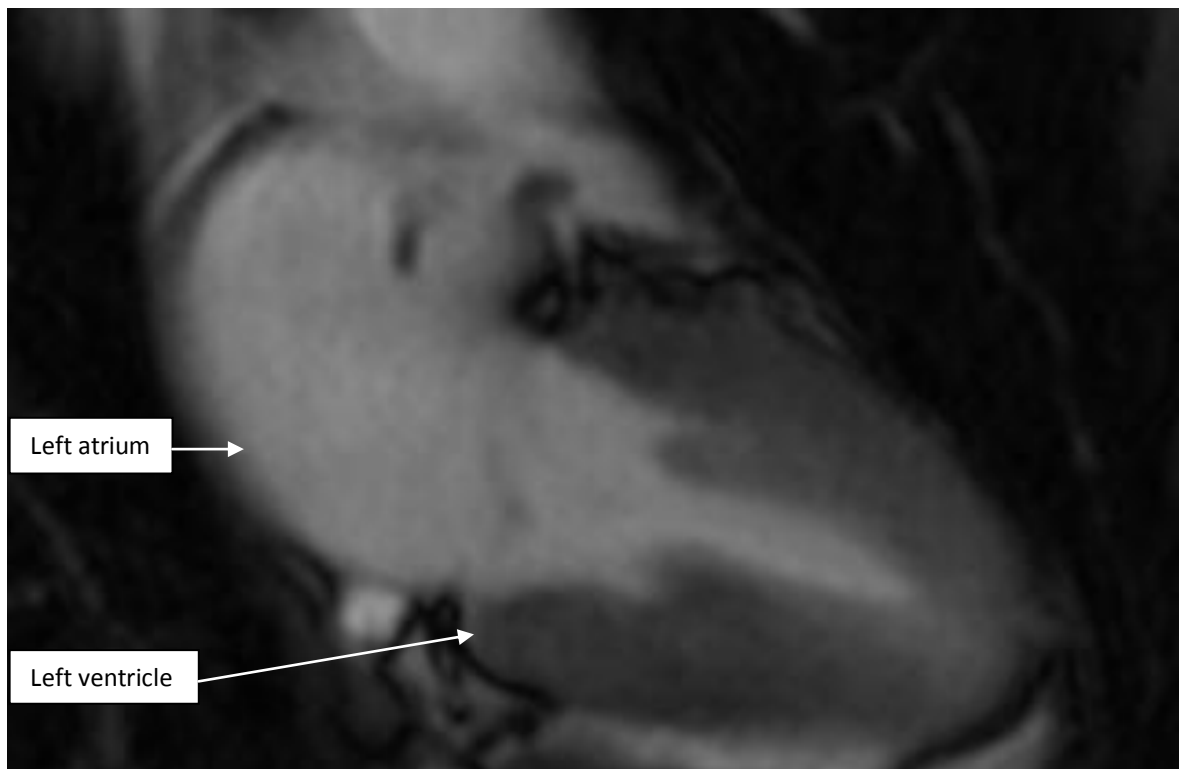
MRI CINE two chamber view (vertical long axis view) of left ventricle at systole
